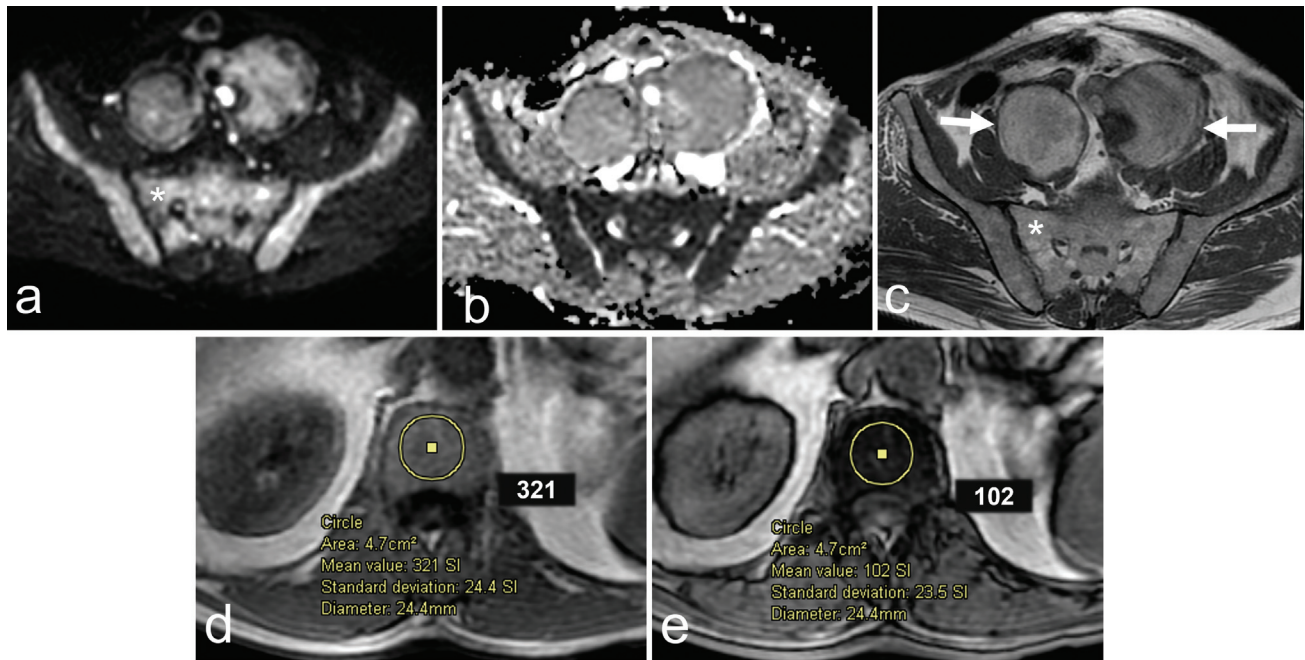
A 65-year-old man with newly diagnosed rectal cancer referred for staging by magnetic resonance imaging (MRI) of the abdomen and pelvis. Transverse (a) diffusion-weighted image (DWI) ($b = 600$) and (b) corresponding apparent diffusion coefficient (ADC) map and (c) T1-weighted images show a diffuse increased signal of the marrow on DWI (a, asterisk) with restricted diffusion (ADC value: $0.62 \times 10^{-3} \text{ mm}^2/\text{s}$) and normal T1 (c, asterisk). Known aneurysms of the iliac arteries treated by endovascular treatment (arrows). Transverse T1-weighted gradient-echo (d) in-phase and (e) out-of-phase images performed in the routine protocol of the abdomen show a 68% signal drop, indicating residual fat in keeping with marrow hyperplasia. The patient had severe anemia (Hb: 6.1 mg/dL).
